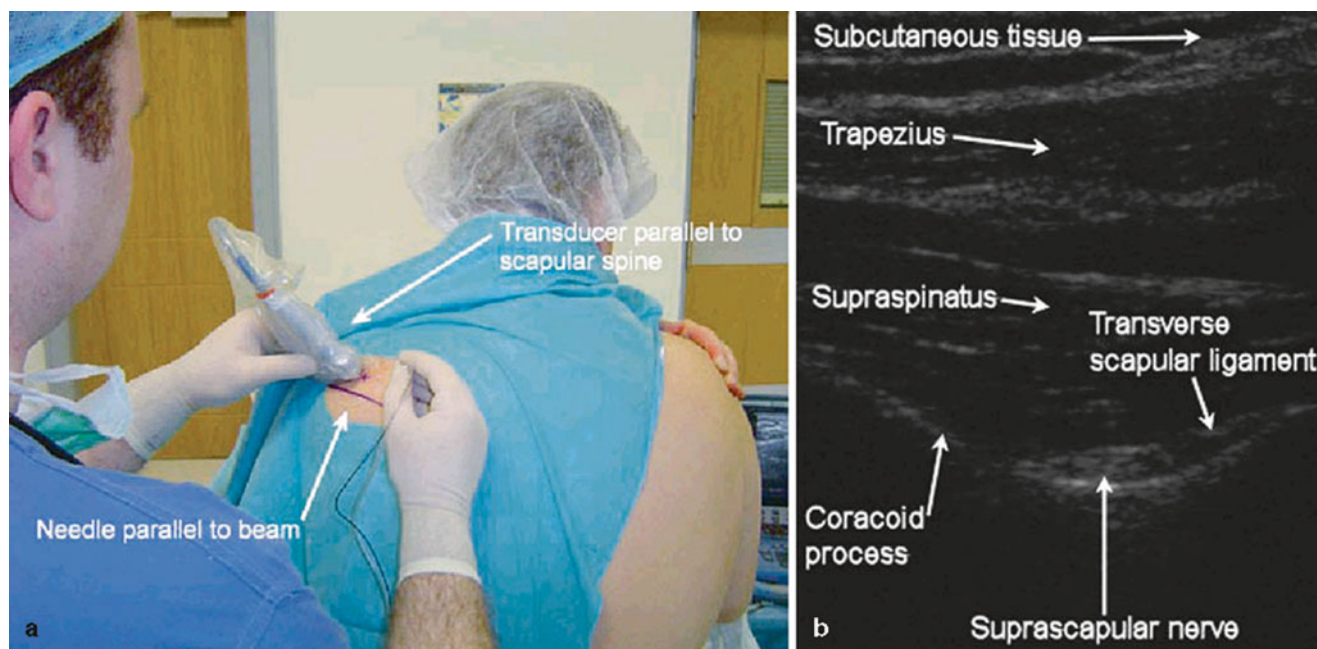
(a) Ultrasound transducer and needle orientation for the ultrasound-guided suprascapular nerve block. (b) Transverse view of suprascapular fossa and scapular notch with a SonoSite ultrasound
